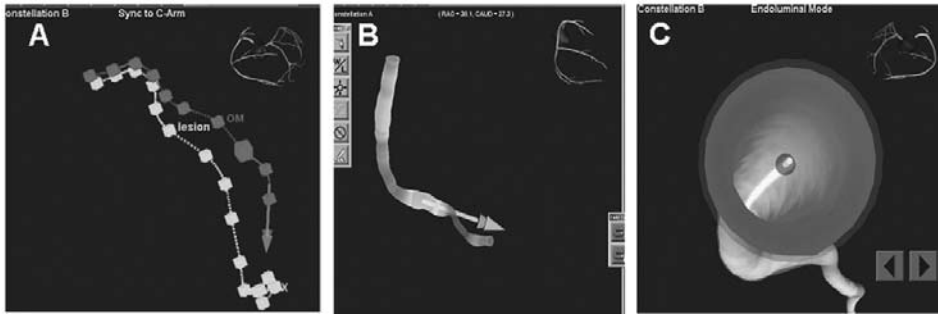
True-vessel navigation using an accurate three-dimensional representation of the coronary artery (A) A constellation road map created from two-dimensional X-ray images; chosen points are depicted by squares along the navigational path. (B) Navigation using a three-dimensional reconstruction created with the CardiOp®-B software. (C) Navigation by means of the endoluminal view. Abbreviation: OM, obtuse marginal branch.
